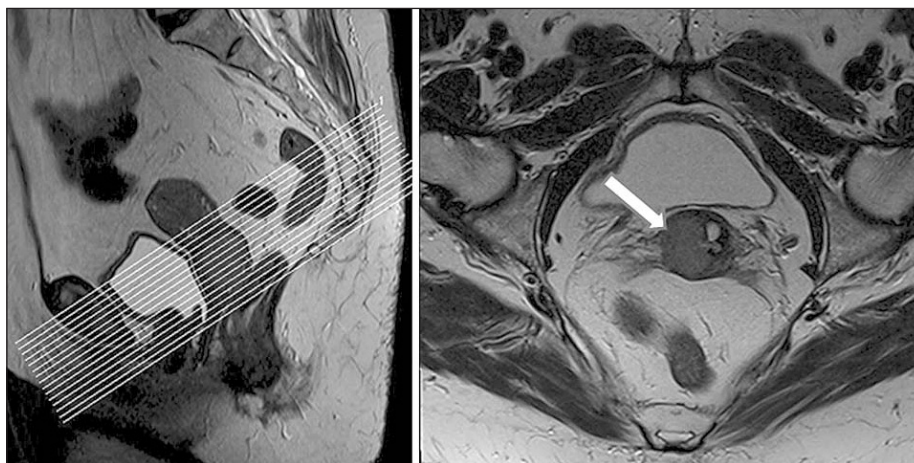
Pelvic MRI T2W sagittal and paraaxial plane (3T, Trio, Siemens) – Infiltration of the cervix uteri, the largest dimension of the lesion is 22 mm. Cervical stromal ring is intact. According to revised classification FIGO IB2.
